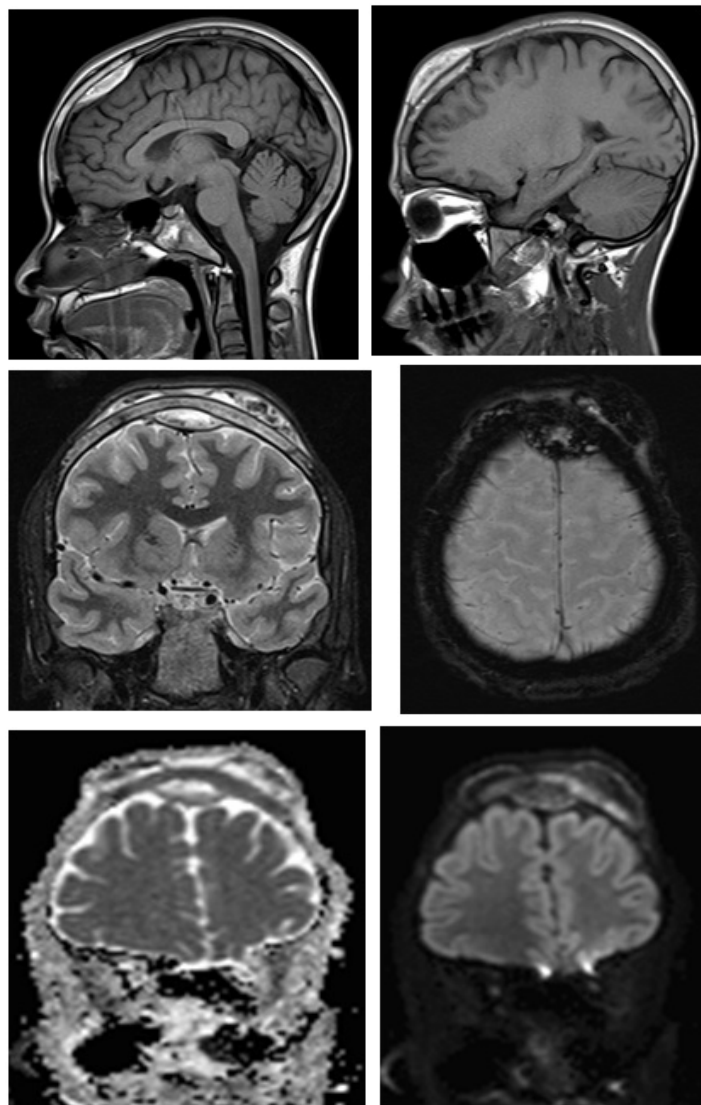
Multiple MRI sequences obtained on the same day as the patient's initial head CT. T1-weighted sagittal images (A and B), T2-weighted coronal STIR (C), susceptibility-weighted imaging (D), ADC map (E), and diffusion-weighted imaging (F). Images demonstrate epidural and subperiosteal collections with associated T1 signal hyperintensity (A and B), heterogeneous T2 signal (C), corresponding susceptibility artifact (D), and no corresponding restricted diffusion (E and F). These findings are consistent with cephalohematomas and epidural hematoma.
